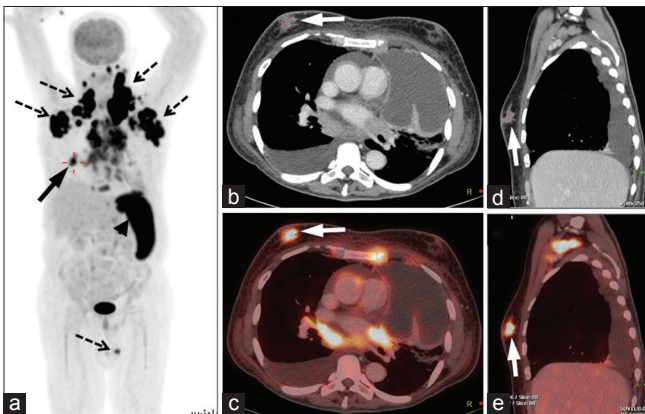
Maximum intensity projection PET image (a) showing hypermetabolic lymphadenopathy both above and below the diaphragm (broken arrows), along with hypermetabolic splenomegaly (arrowhead). Also noted was focal ^{18}F -FDG uptake in right anterior chest wall (bold arrow). Transaxial and sagittal CT and PET-CT (b-e) images of the thorax showing focal hypermetabolism involving right breast nodule measuring 17 mm × 15 mm, suggesting involvement (bold arrow). ^{18}F -FDG PET-CT: ^{18}F -fluorodeoxyglucose positron emission tomography-computed tomography
